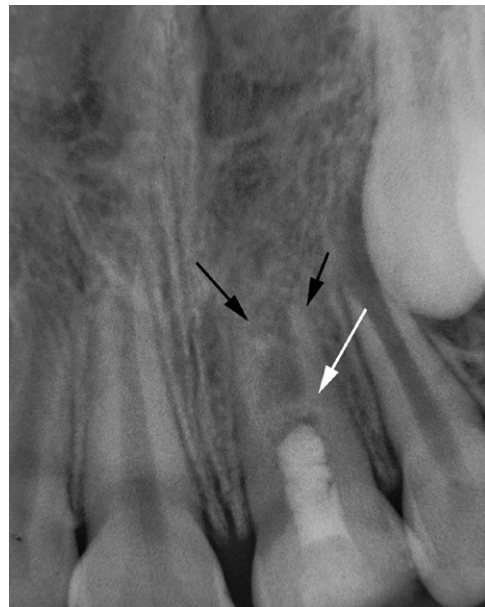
Seven-month-recall radiograph showing dentinal bridge formation (white arrow) and increased thickness of the root canal wall apical to the MTA (black arrows). (Reprinted with permission from Paniagua, 2010, with permission from CES Odontología.)
